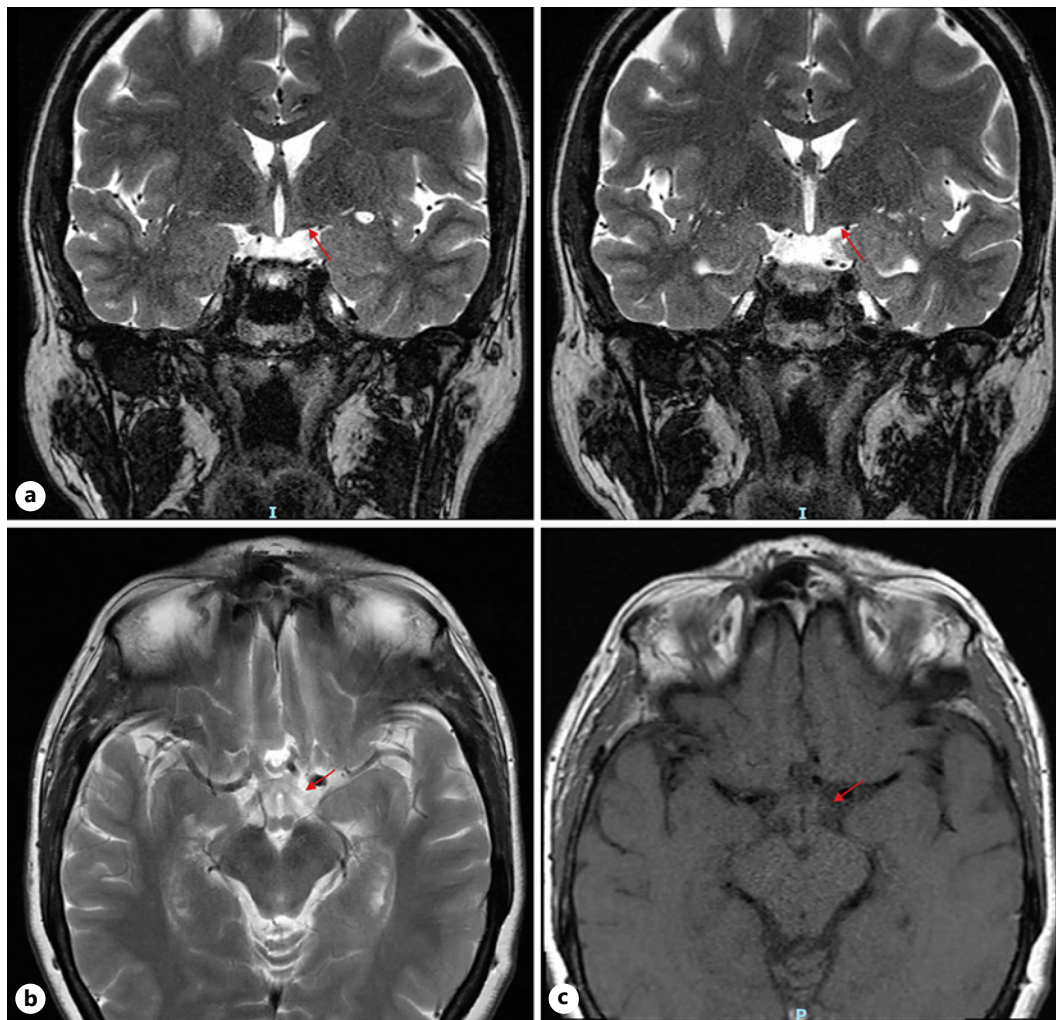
MRI of the brain showing subtle thinning of the left optic tract on coronal T2 (a), axial T2 (b), and axial T1 images (c). MRI, magnetic resonance imaging.
